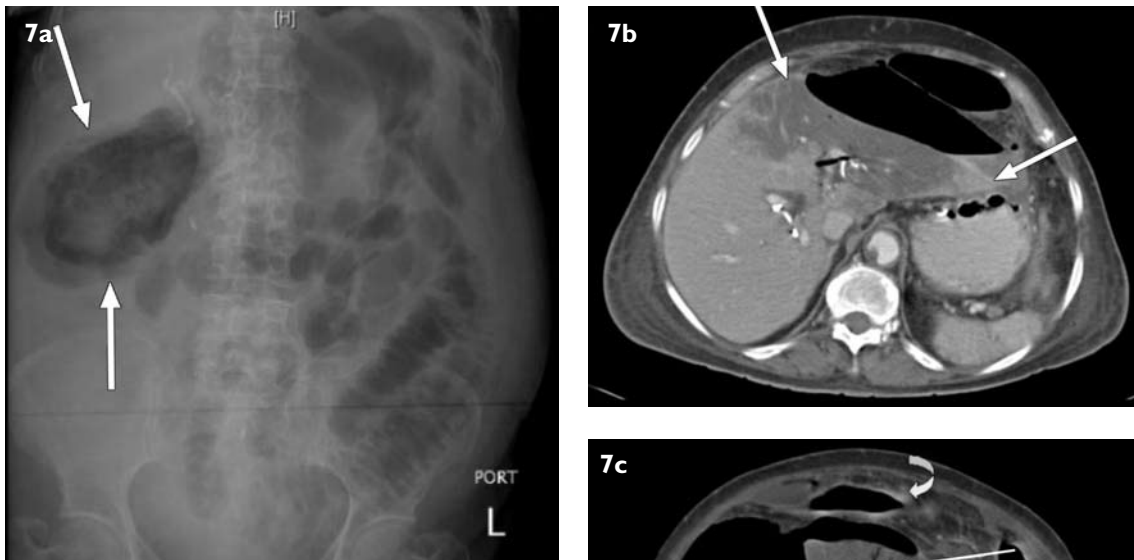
A 56-year-old woman presented with vomiting and abdominal distension. (a) Abdominal radiograph shows branching lucencies in the right hypochondrium, in keeping with portal venous gas (arrowheads), with marked dilatation of the stomach and the proximal duodenum. Curvilinear lucencies in the duodenum (arrow) were due to intramural gas. (b) Axial CT image confirms the radiographical findings of portal venous gas (arrow). (c) Axial CT image also shows intramural gas within the duodenal wall (arrows). The transition point was at the level of the third part of the duodenum, between the aorta and the superior mesenteric artery (curved arrow), raising the possibility of superior mesenteric artery syndrome.
